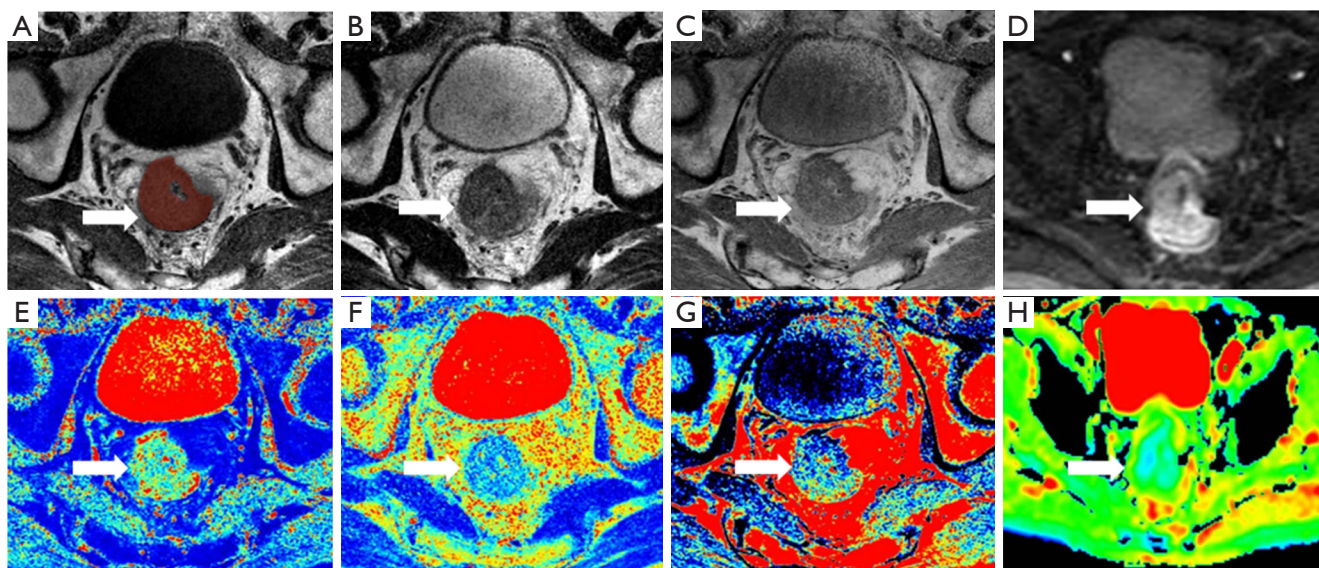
A 71-year-old man with moderate differentiation RC [T3N0, mesorectal fascia (-), extramural venous invasion (-)]. (A-C) synthetic T1-, T2-, and PD-weighted images, respectively; (D) axial DWI ($b = 800 \text{ s/mm}^2$); (E-G) T1, T2, and PD maps derived from SyMRI indicating the mean T1, T2, and PD values, which were drawn along the contour of the tumor on the slice with the largest tumor diameter were 1,174 ms, 82 ms, and 78 pu, respectively. (H) ADC map indicates that the mean ADC value was $1,070 \times 10^{-6} \text{ mm}^2/\text{s}$. The arrow points to the tumor. RC, rectal cancer; DWI, diffusion-weighted imaging; ADC, apparent diffusion coefficient; PD, proton density; SyMRI, synthetic magnetic resonance imaging.
